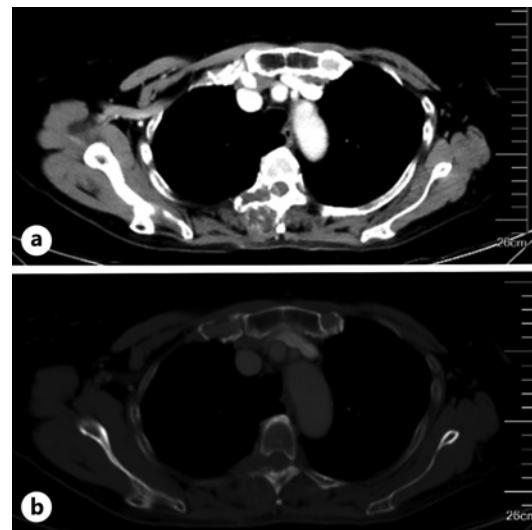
a, b The chest thoracic computed tomography scan reveals a mixed-type extensive lytic lesion involving the right appendage and adjacent ribs from T1 to T5. The lesion exhibits radiolucent components and peripheral sclerosis, encompassing the right pedicle, vertebral body, and transverse process, with T4 being the most severely affected and extending into the spinal canal through the intervertebral foramen.
